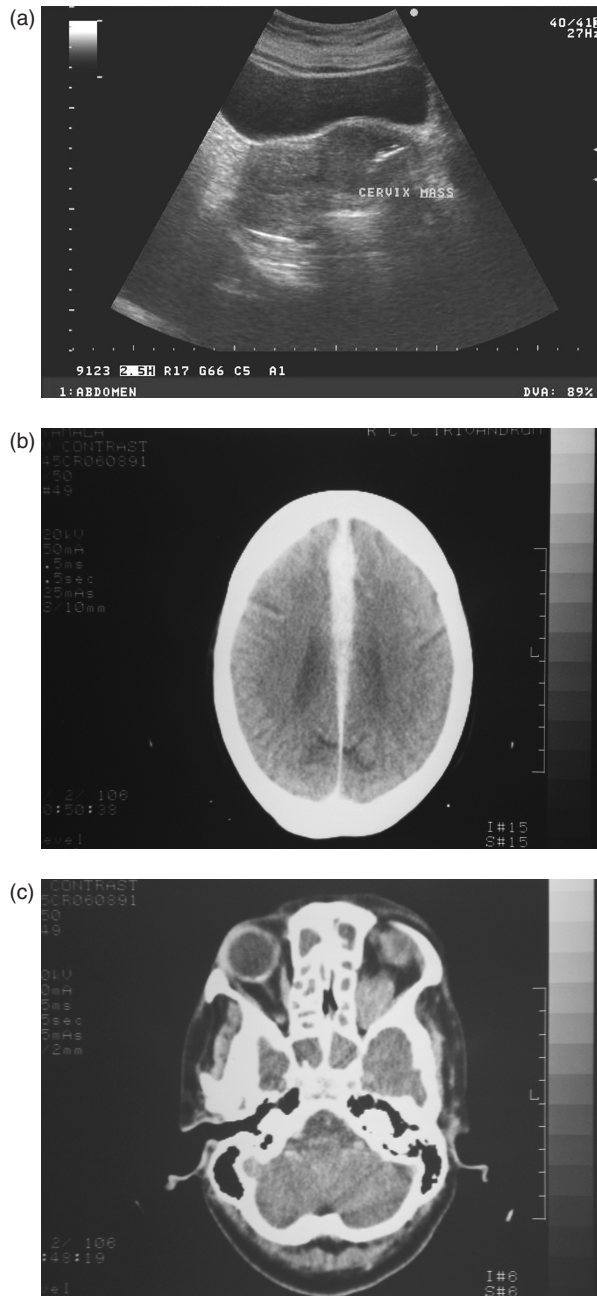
(a) Ultrasound image showing the mass in the cervix; (b) contrast enhanced CT showing enhancement along the falx cerebri; (c) contrast enhanced CT showing a lobulated mass in the left orbit involving the optic nerve.
